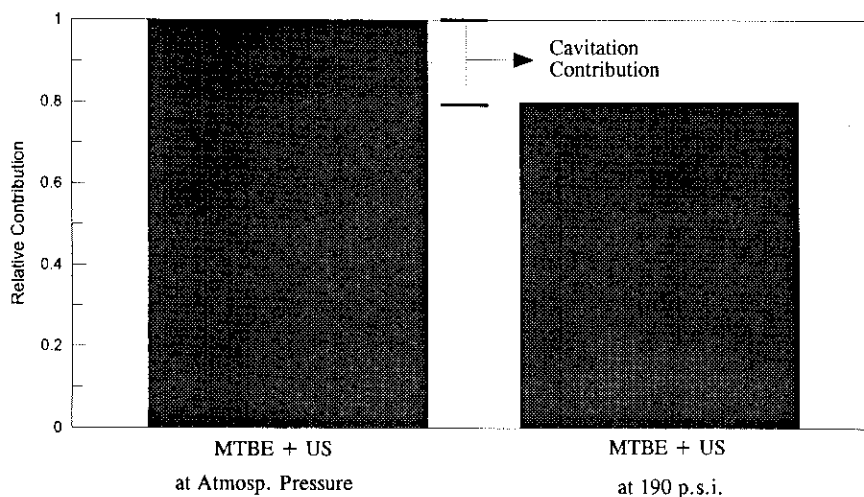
Relative contribution of cavitation to gallstone weight reduction in MTBE with ultrasound (US) applied for 35 min *in vitro*.
